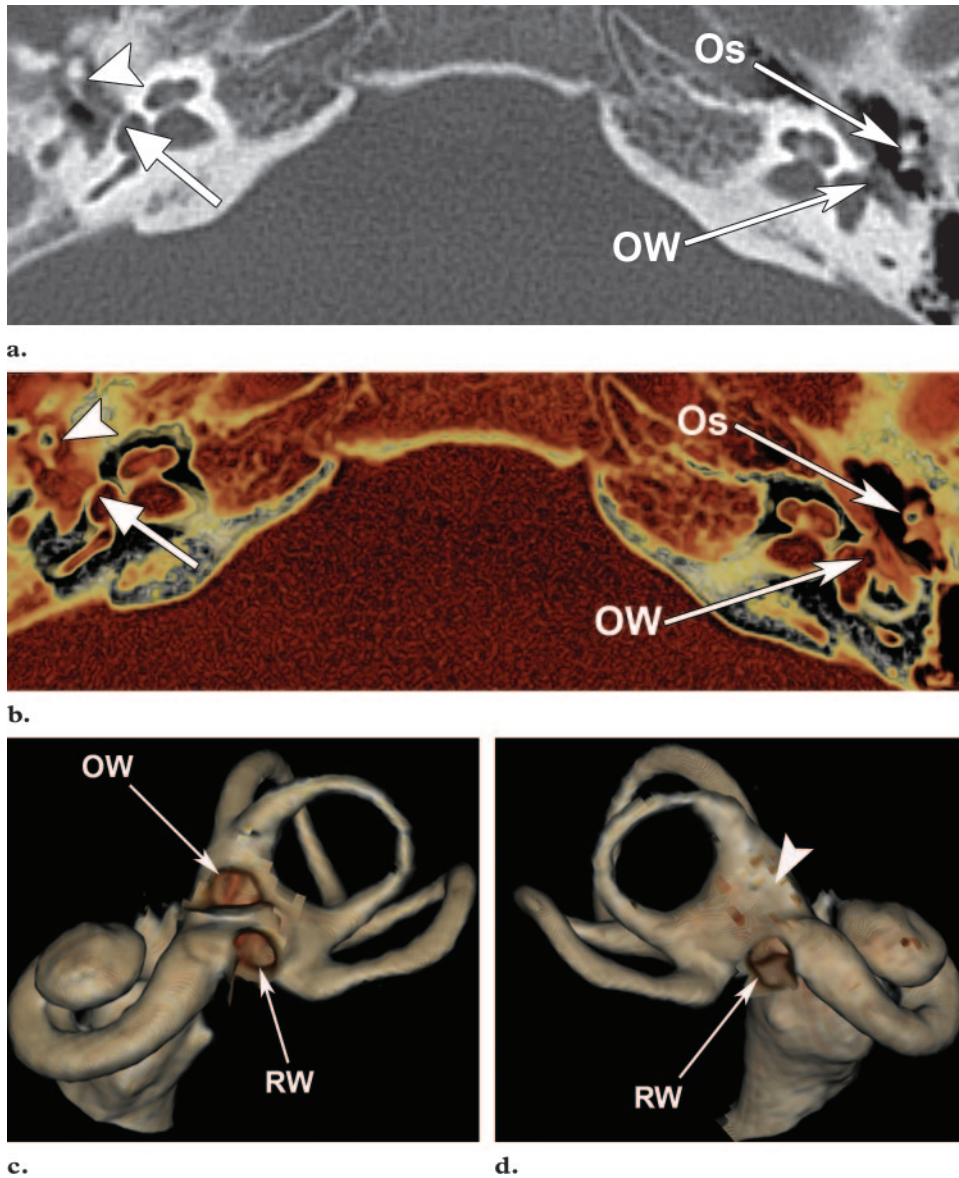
Congenital ossicular malformation with oval window atresia in a 12-year-old boy with right-sided mixed hearing loss. (a, b) CT scan (a) and corresponding 3D CT reformatted image (b) show malformed ossicles with an associated soft-tissue mass (arrowhead) attached to the lateral wall of the right tympanic cavity. A suspicious platelike covering (arrow) is seen in the expected region of the right oval window. The left-sided ossicles (*Os*) and left oval window (*OW*) are normal. (c) Three-dimensional VR CT image (inferolateral view) shows a normal left bony labyrinth with the oval window (*OW*) and round window (*RW*) well depicted. (d) Three-dimensional VR CT image (inferolateral view) shows an abnormal right bony labyrinth with absence of the oval window (arrowhead). *RW* = round window.
